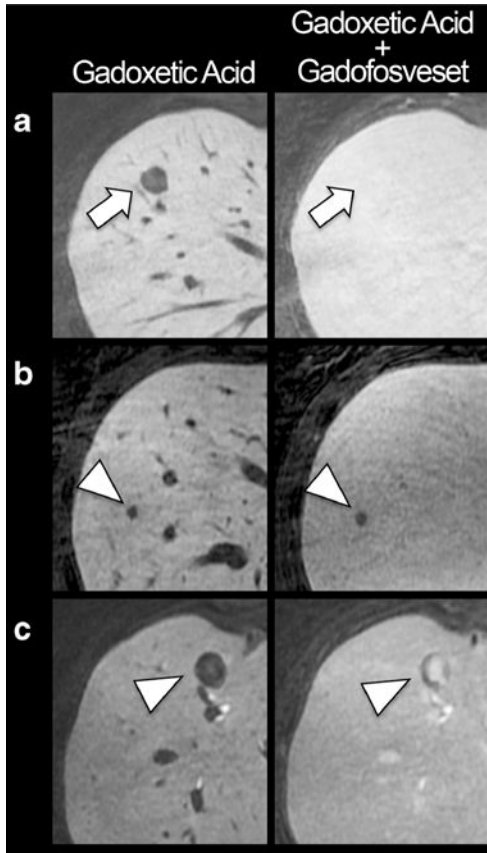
Different enhancement patterns of haemangiomas and metastases. All lesions appear hypointense compared the liver tissue on gadoxetic acid alone enhanced liver MRI. a Example of a 50-year-old woman with haemangioma (*arrow*). The additional injection of gadofosveset in the hepatobiliary phase of gadoxetic acid renders the haemangioma isointense to liver tissue. b Example of a 58-year-old woman with a metastases of colorectal cancer, showing no or negligible enhancement after injection of gadofosveset (*arrowhead*). c Example of a 51-year-old man with metastases of a neuroendocrine carcinoid tumour, showing central enhancement after injection of gadofosveset (*arrowhead*)
